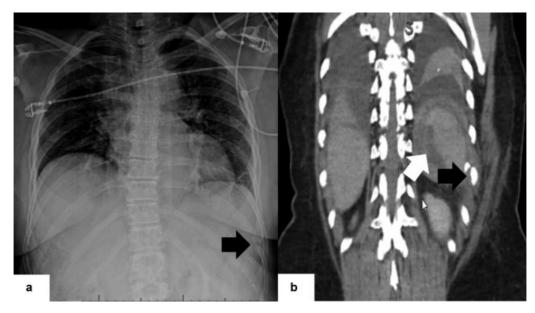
(a) Chest radiograph obtained after a motor vehicle collision demonstrates a fracture of the left 10th rib (black arrow). (b) Coronal reformat image from a contrast-enhanced CT scan in the same patient demonstrates the fracture seen on radiography (black arrow) and hemoperitoneum from associated splenic trauma in the left upper quadrant (white arrow).
